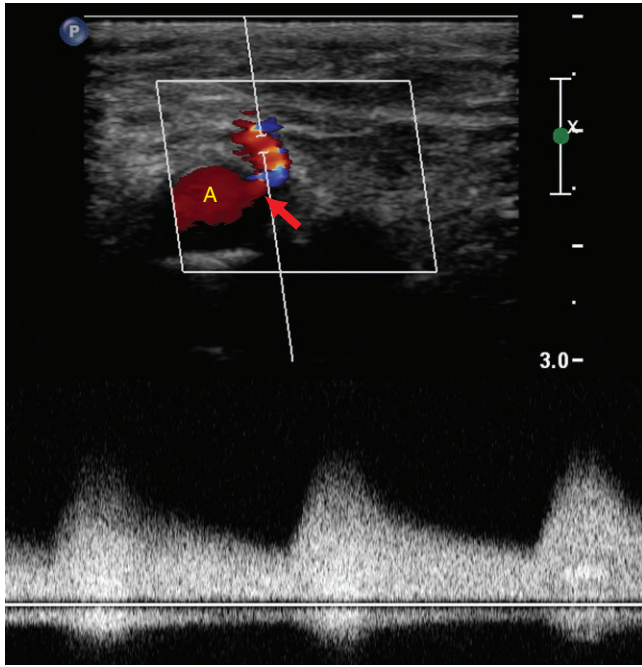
The common femoral artery (A) demonstrates a tract anteriorly at 3 o'clock (arrow). There is color aliasing in the tract. Spectral Doppler in the tract shows a low pulsatile waveform with high systolic and diastolic flow. The continuous forward flow is typical of an arteriovenous fistula and does not demonstrate the “to and fro” of a pseudoaneurysm neck nor the normal forward and reverse flow of a normal arterial branch.
